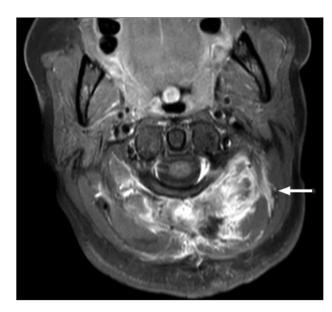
T1-weighted MRI scan showing the presence of scar tissue at the previous tumour site 6 months post-operatively. There is no evidence of residual tumour.
